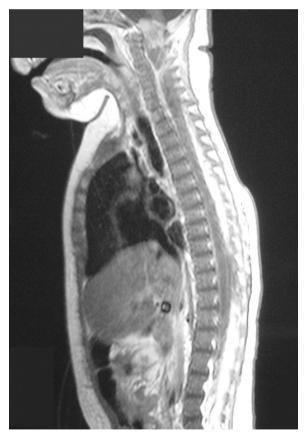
Initial Magnetic Resonance Imaging of the spinal cord. Sagittal T1-weighted image show an intradural, extramedullary mass occupying the spinal canal at the level of C1-C5.
